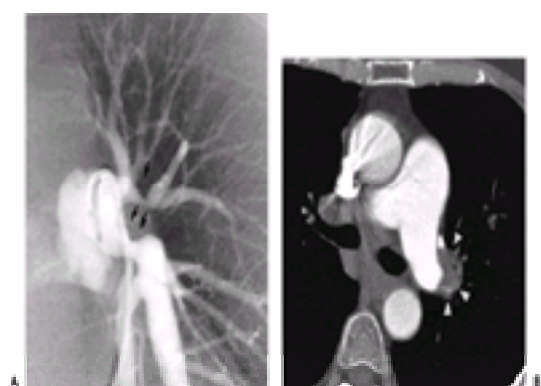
Histoplasmosis. A: Left pulmonary arteriogram in a patient being evaluated for chronic pulmonary thromboembolism. Multiple eccentric stenoses are present (arrows). B: Contrast-enhanced CT scan at the level of the left pulmonary artery demonstrates calcified, enlarged lymph nodes (arrowheads) in the region of angiographic abnormality. The mediastinum is diffusely abnormal, containing soft-tissue attenuation material. (Images courtesy of Ulf Nyman, Sahlgrenska University Hospital, Goteborg, Sweden.)
